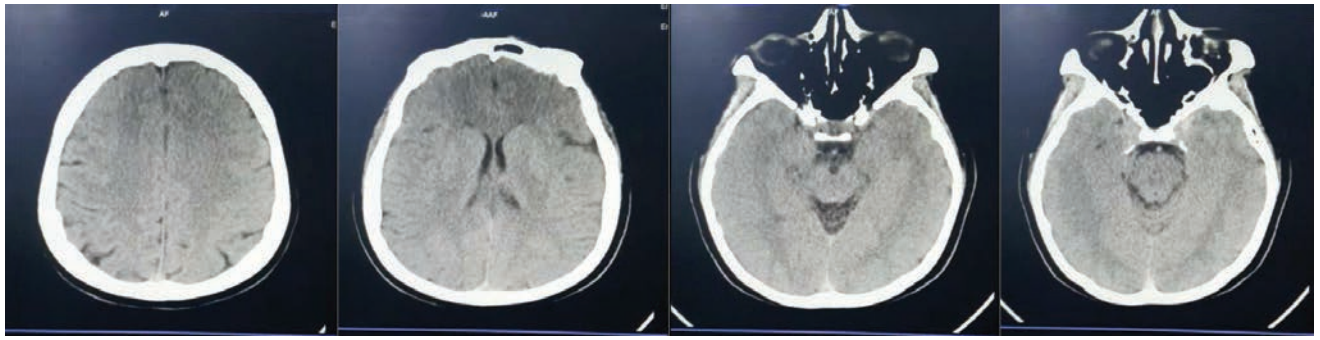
The density of gray and white matter, the gyrus and cerebral sulcus, the ventricular system, and the subarachnoid space were all within normal limits, as determined by a head CT without contrast. There was no obstruction or deviation of the paranasal sinuses or nasal septum
